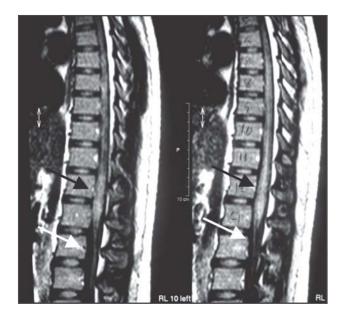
Magnetic resonance imaging of the patient in Figure 1a. Black arrows point to a dilated conus medullaris. This is a T1-weighted image with a diffuse granular impregnation of the spinal cord after endovenous gadolinium injection (whitish areas of the spinal cord). There is also impregnation of contrast of the cauda equina (white arrows).
